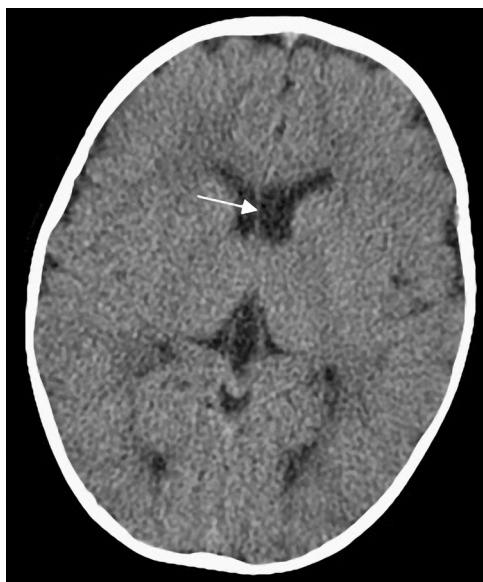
Axial non-contrast CT scan of the brain showing an asymmetrical septum pellucidum to the right (white arrow).
